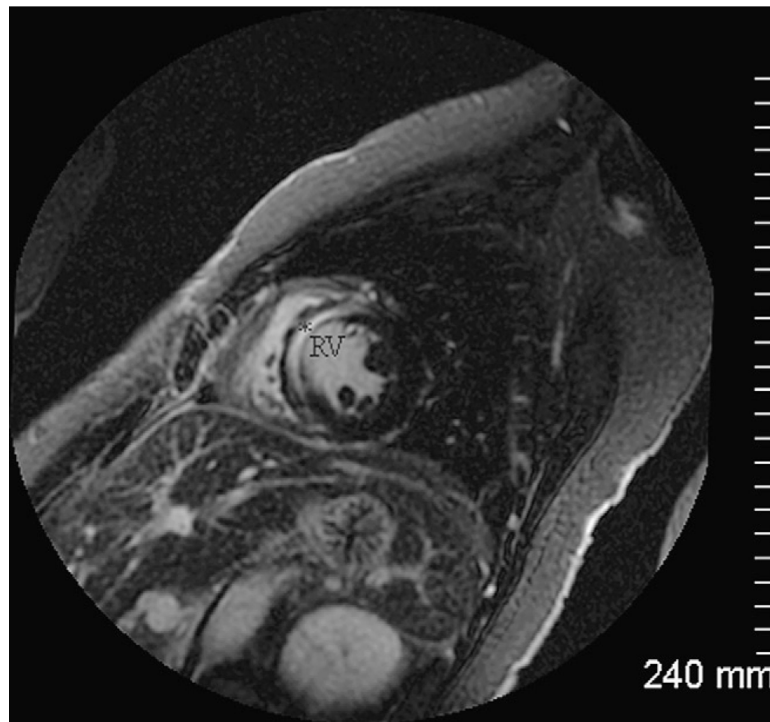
Cardiac magnetic resonance imaging shows evidence of late gadolinium enhancement (asterisk) confined to the subendocardial portion of the septal myocardial wall of the right ventricle (RV) on inversion recovery images in the short-axis plane indicating myocardial damage.
